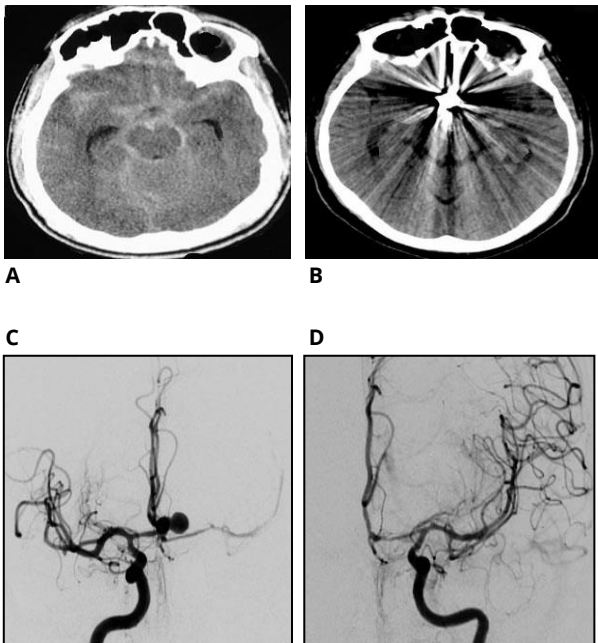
A,B - Brain CT diagnosis highlighting SAH and post interventional brain CT control; C,D,E - ; D,E - DSA from the right and left ICA showing the double AcomA aneurysm; F,G,H,I,J- Intraprocedural DSA images and the final DSA control from both ICA injection.
